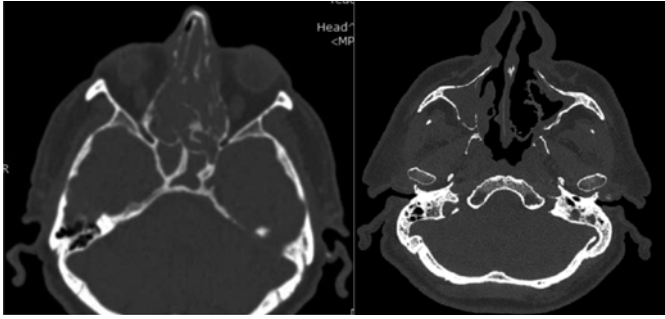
Paranasal sinuses CT scan, axial section. Before and after the surgery.
